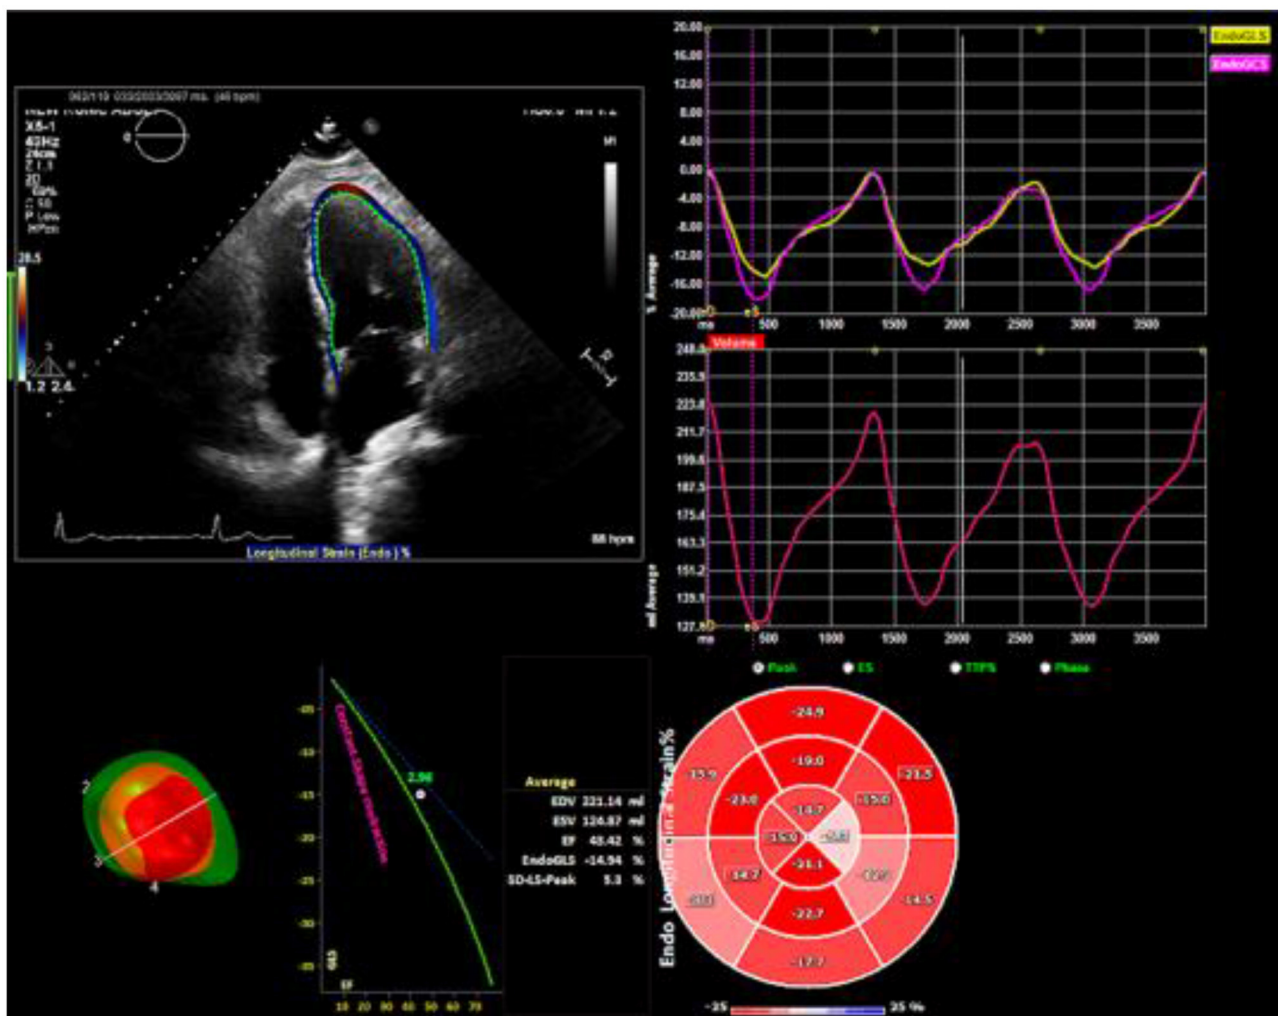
Two-dimensional speckle tracking echocardiography analysis. Strain curves and a color-coded 16-segment bull's eye plot are presented. Color lines indicate regional strain. Values of longitudinal strain are negative (sign -). Endocardial border tracing in apical four-chamber view can be achieved automatically. Global longitudinal strain (GLS) can be calculated from standard apical 4-, 2-, and 3- chamber views.
